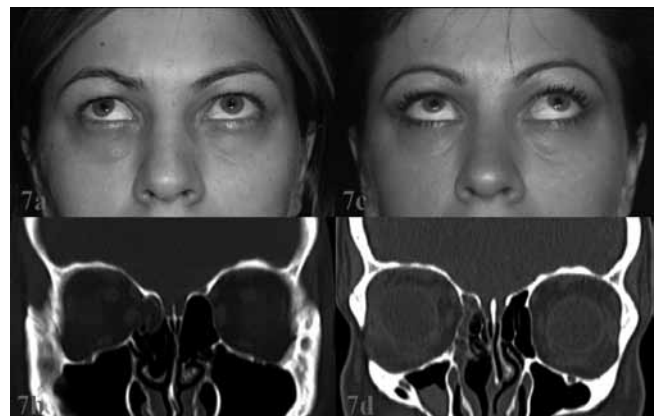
Preoperative frontal axial view (a) of the patient and pre-operative coronal CT scans (b). Limited movement of the right eye in the upper gaze was evident along with fracture of right orbital medial wall. Postoperative frontal view (c) of the patient and postoperative coronal CT scans (d). A biocompatible collagen membrane was positioned on the right orbital floor to the medial wall; left enophthalmos and diplopia disappeared, and right ocular rotations improved.
